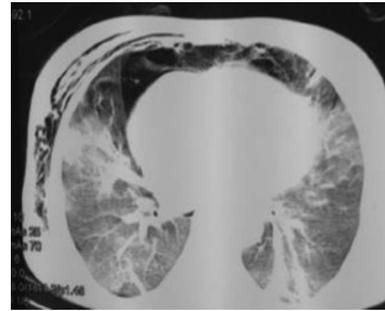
Pneumomediastinum on computed tomography
